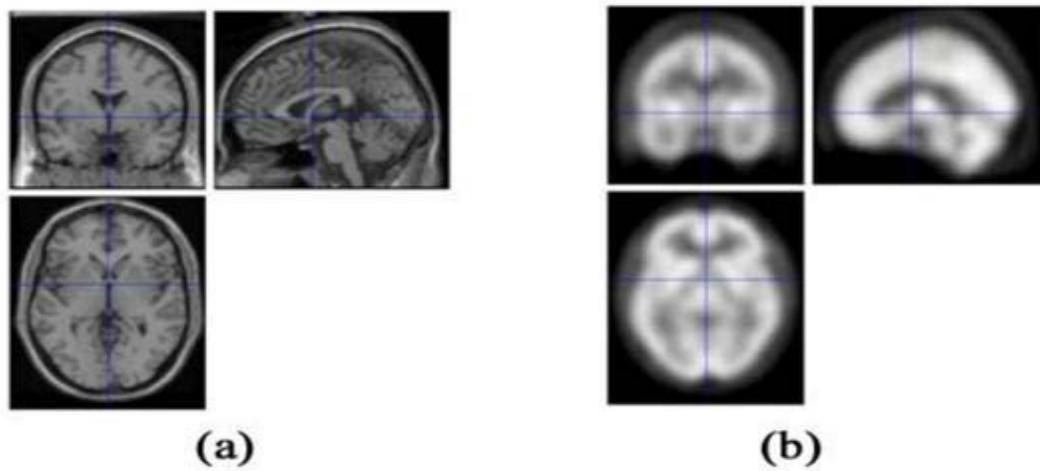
Presentation of the models used (a): MRI atlas image, (b): Template SPECT.
